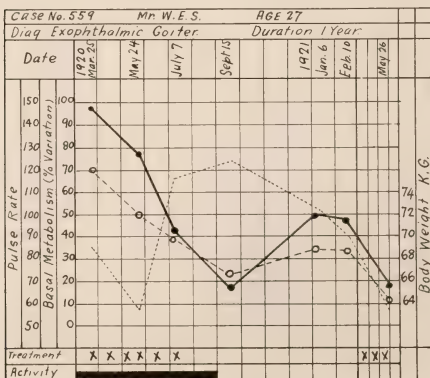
Figure III—Case No. 559. Exophthalmic goiter. Graphic chart showing change occurring in the basal metabolic rate and pulse. X-ray treatment indicated at the bottom by a cross.
